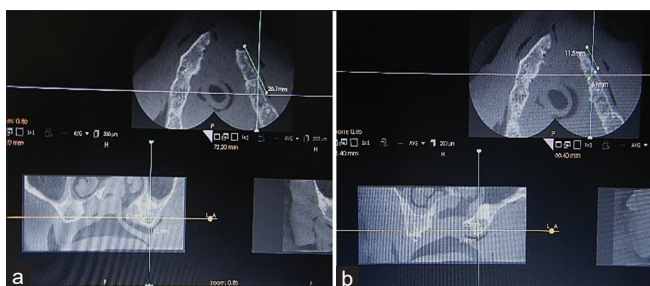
(a and b) Cone-beam computed tomography scan showing a wide alveolar defect involving almost the entire premaxillary segment of the maxillae
